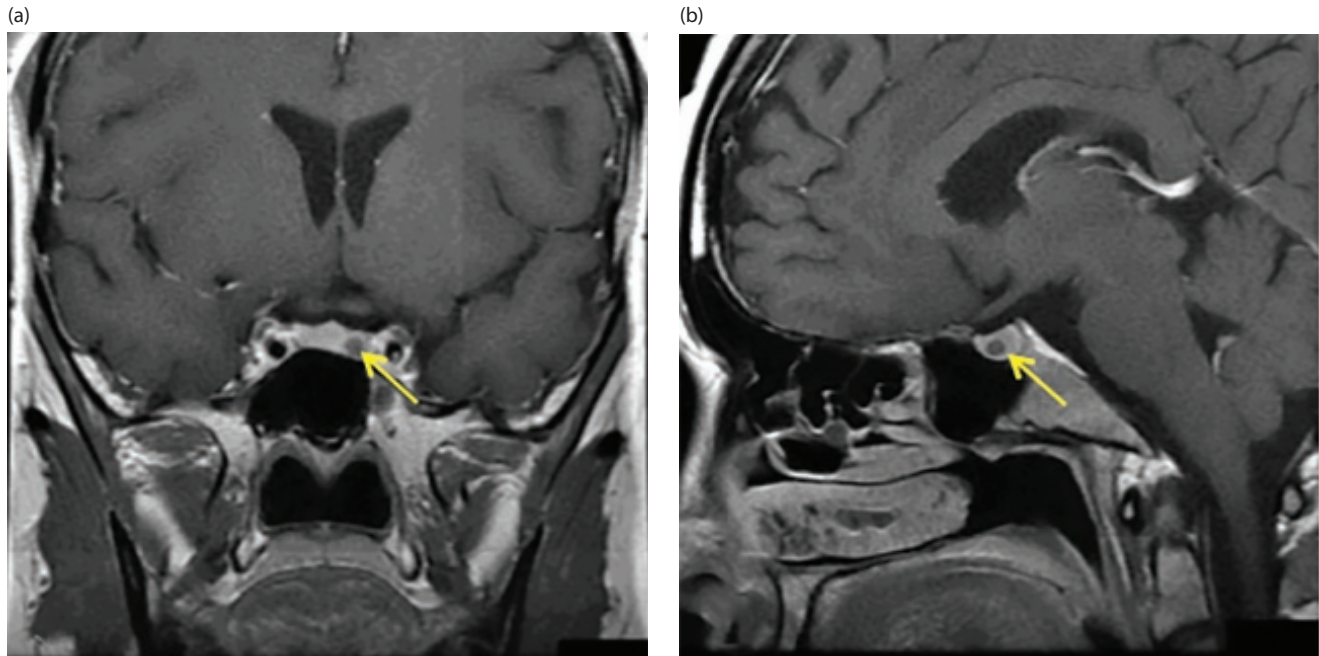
Coronal (a) and sagittal (b) post contrast MRI showing a non-functioning microadenoma.
